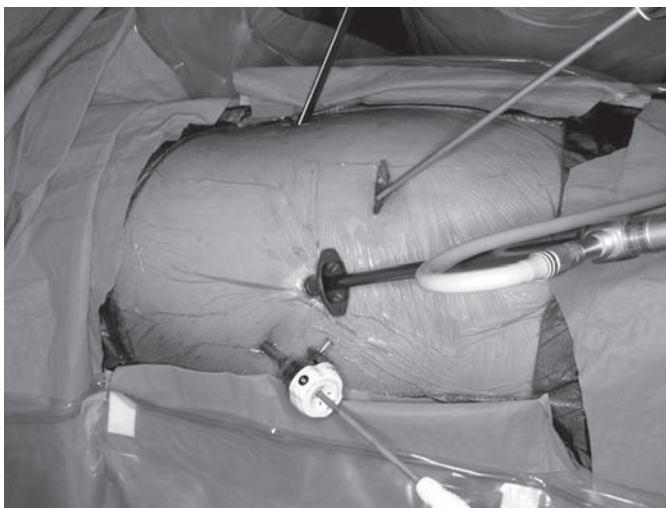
Transthoracic Ivor Lewis—minimally invasive steps 1 and 2.
